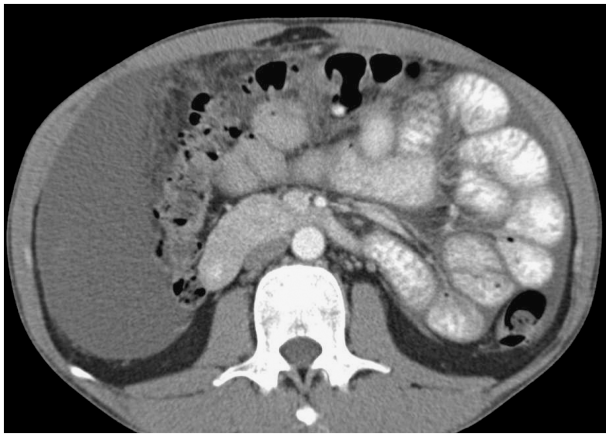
CT abdomen showing large volume ascites, with normal bowels and no evidence of obstruction.
